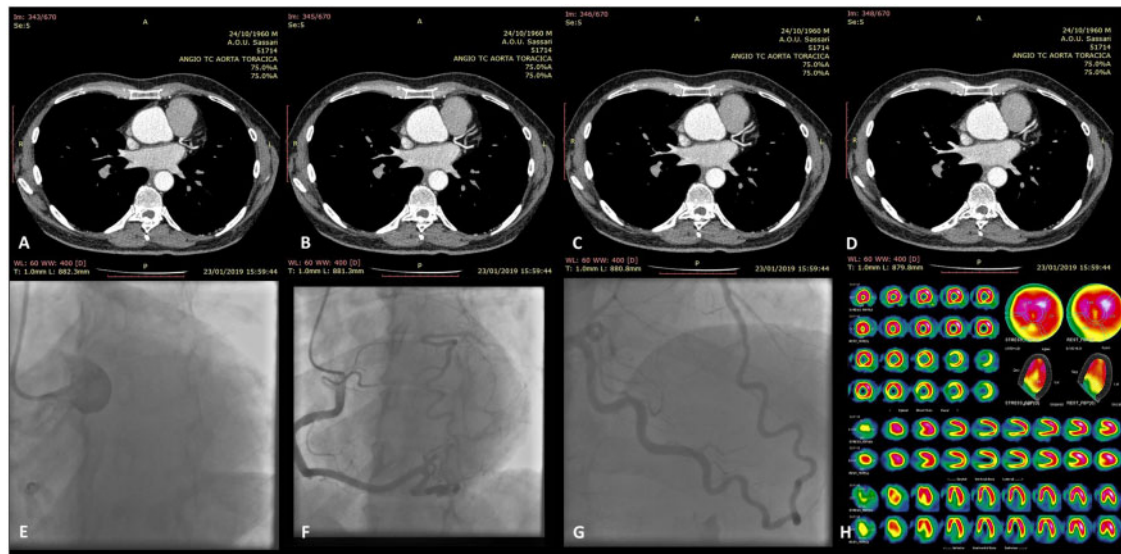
(A–D) Computed tomography images with progressive filling of contrast are shown; in the left main coronary atresia, the left anterior descending artery, and circumflex artery are connected as usual but proximally end blindly. (E) Injection of contrast in the left sinus of Valsalva confirming left main coronary atresia. (F) The right coronary artery provides a collateral circulation for the left coronary artery. (G) The calibre of coronary collaterals was similar to that of the target left-sided vessels. (H) Myocardial single-photon emission computed tomography during maximal exercise-stress test did not show perfusion defects as compared to rest.
